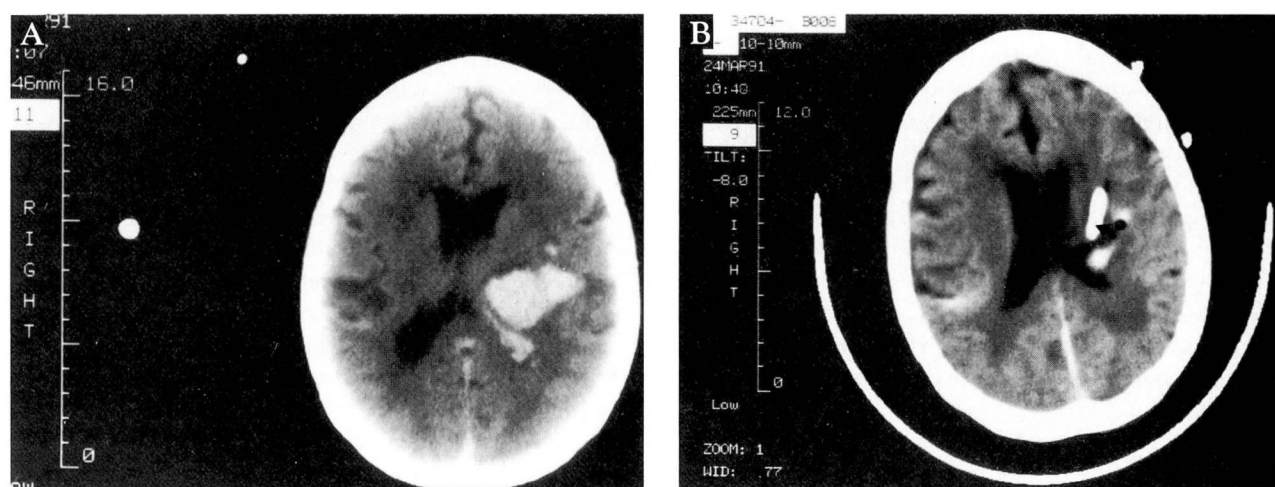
Unenhanced computed tomographic scan of left thalamic hemorrhage (A) in a 67-year-old hypertensive woman with global aphasia and right hemiplegia. After urokinase treatment (B), the clot volume is substantially reduced. The catheter tip is clearly seen (arrow). The patient was discharged to rehabilitation 3 weeks after treatment, at which time she could move her right lower limb, verbalize, and follow simple instructions.
